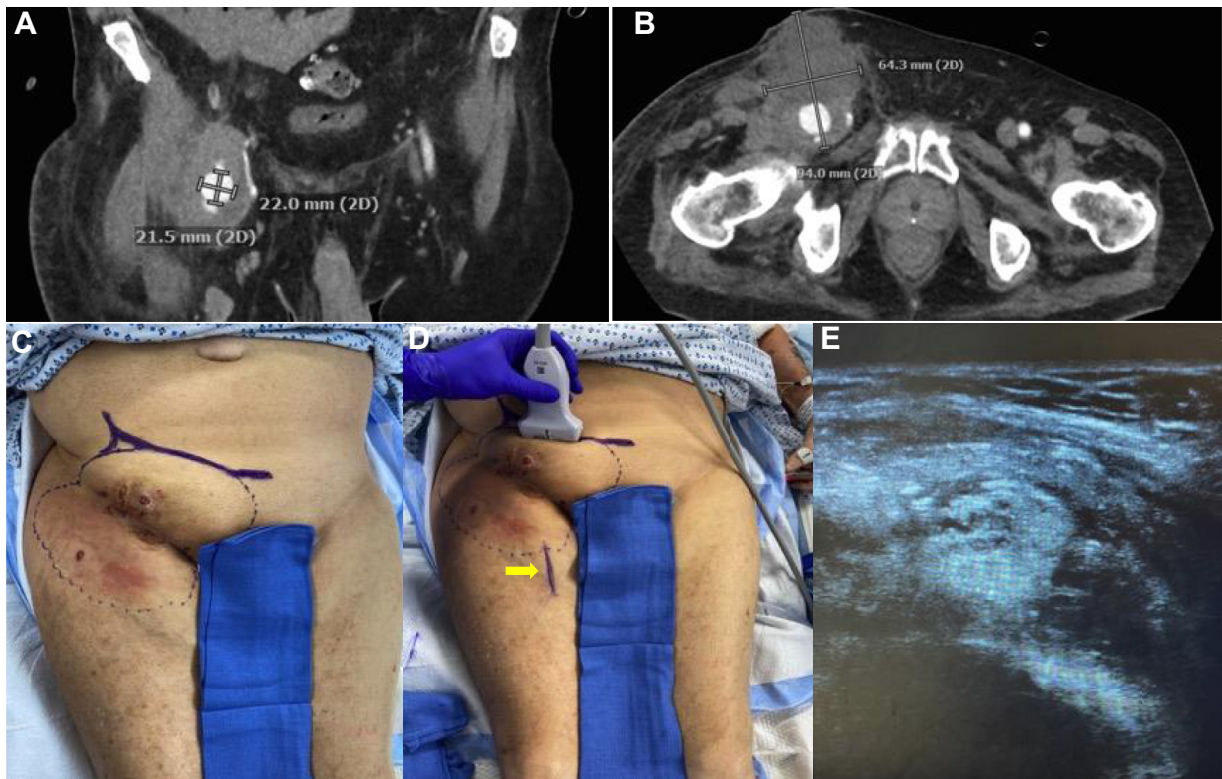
Preoperative imaging. A, Coronal view of right common femoral artery (CFA) pseudoaneurysm with patent vessel measuring 22.0 × 21.5 mm on computed tomography angiography. B, Axial view of right CFA pseudoaneurysm measuring a 94.0 × 64.3 mm. C, Preoperative image of right groin mass. D, Preoperative ultrasound imaging of pseudoaneurysm and vasculature; yellow arrow denotes the ultrasound mapped course of the right superficial femoral artery (SFA). E, Preoperative ultrasound image of CFA pseudoaneurysm in relation to the inguinal ligament.
